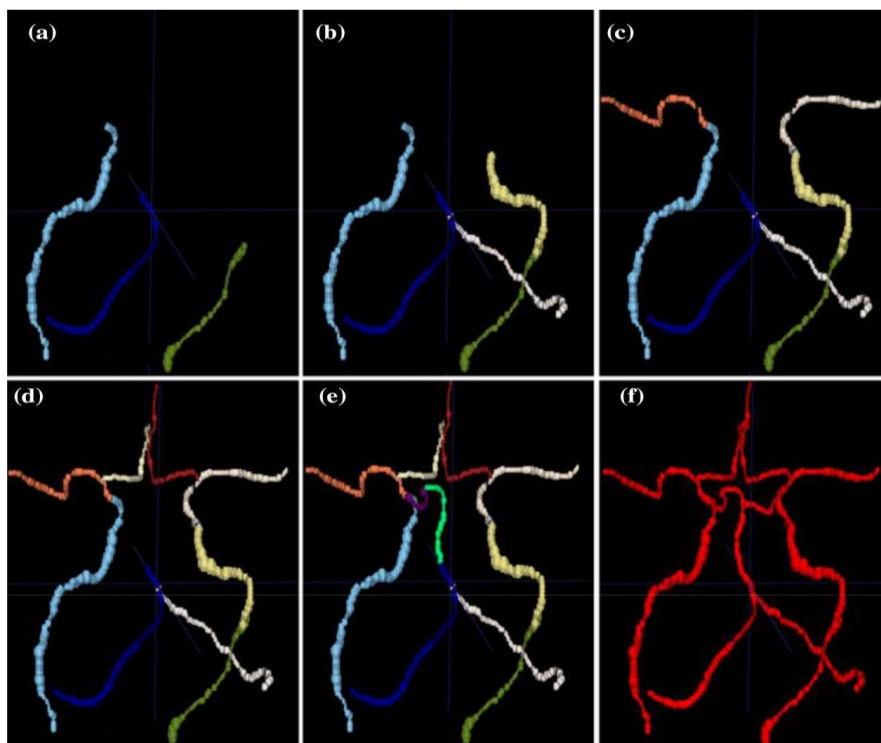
Six phases of segmentation of vasculature from a CTA image (Data id-3036)
